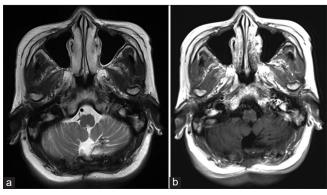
Postoperative images. (a) Postoperative T2weighted images and (b) contrast-enhanced T1-weighted images show that the mass is totally excised.
